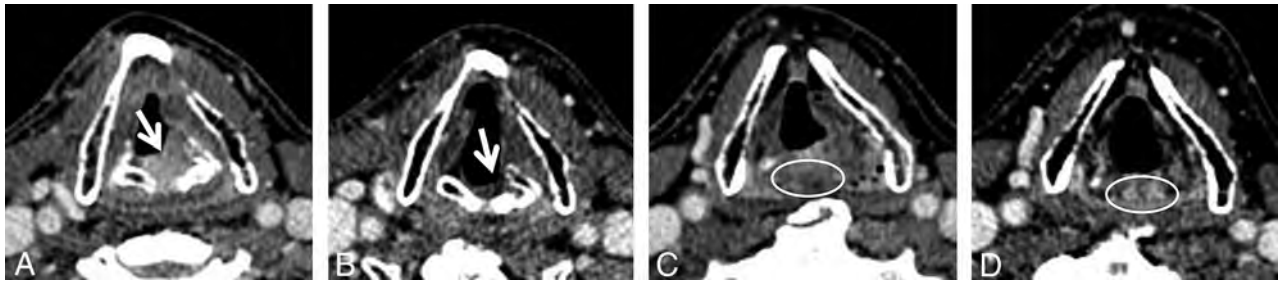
Axial contrast-enhanced neck CT images obtained before (A and C) and after (B and D) definitive radiation therapy for laryngeal squamous cell carcinoma (arrow, A). Posttreatment images demonstrate a substantial decrease in size of the treated tumor (arrow, B) as well as prominent PCVP (circle, D) that was not definitively identifiable on the baseline pretreatment neck CT (circle, C). The prominent PCVP (circle, D) was described as suspicious for progressive neoplasm but confirmed to be vascular after 22 months of imaging follow-up.
